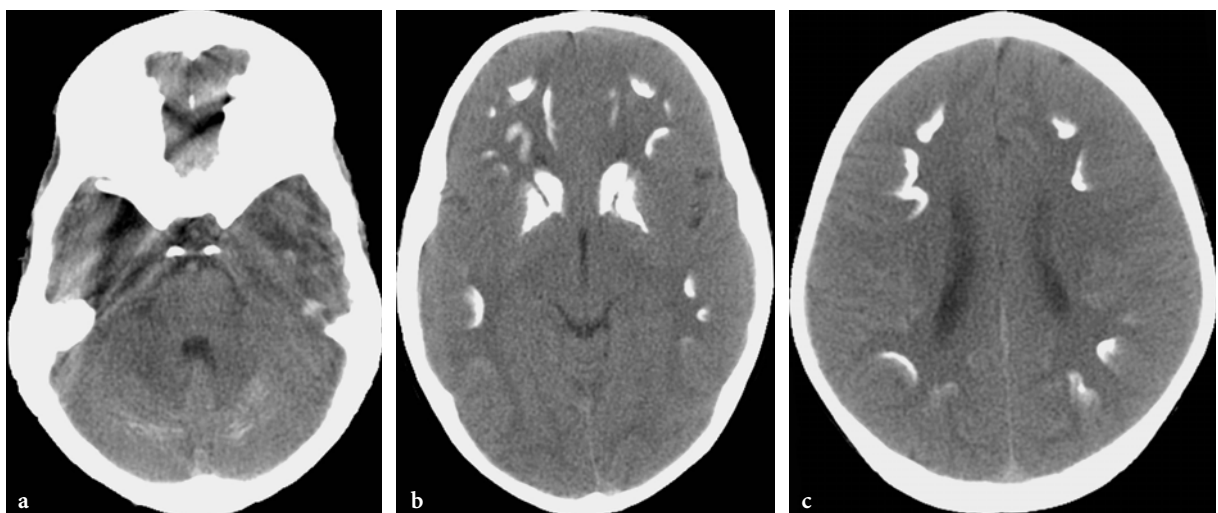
CT abnormalities in “malignant” bipterin dependent form of phenylketonuria in an 11-year-old male patient. a–c Unenhanced axial CT images of brain show prominent calcifications at the level of basal ganglia and subcortical white matter structures. Faint hyperdensities are also seen within the cerebellum
